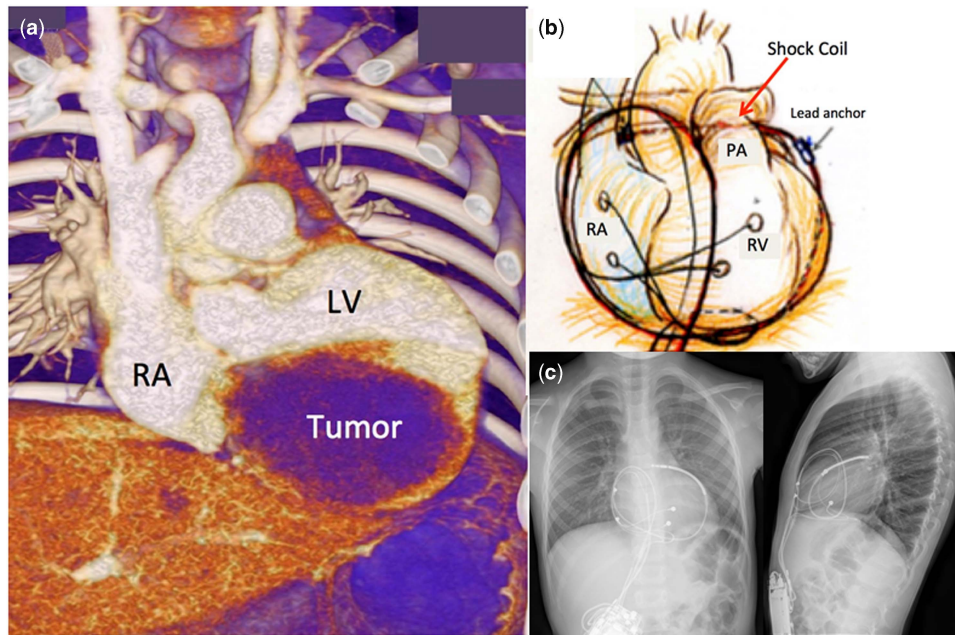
(a) Contrast CT scan (3D reconstructed) showing the tumour originating from the left ventricular inferior wall. (b) A coil lead was placed through the transverse pericardial sinus and sewn to the posterior pericardial wall. (c) Post-operative chest X-ray (two-direction).
